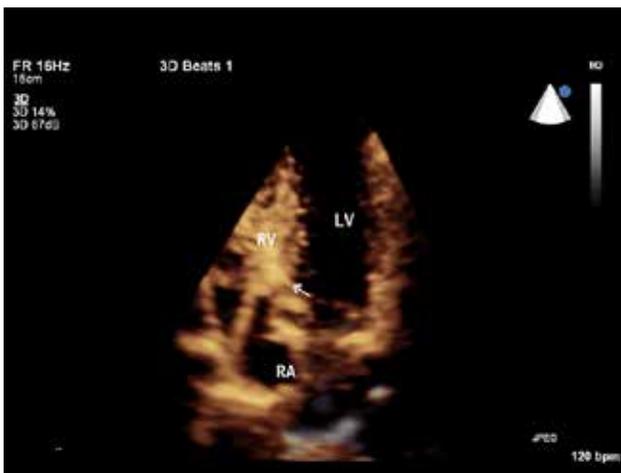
Transthoracic 3-dimensional echocardiography confirming location of the pellet (white arrow) in the side of the interventricular septum facing the right ventricle, 12 mm above the tricuspid annulus.
